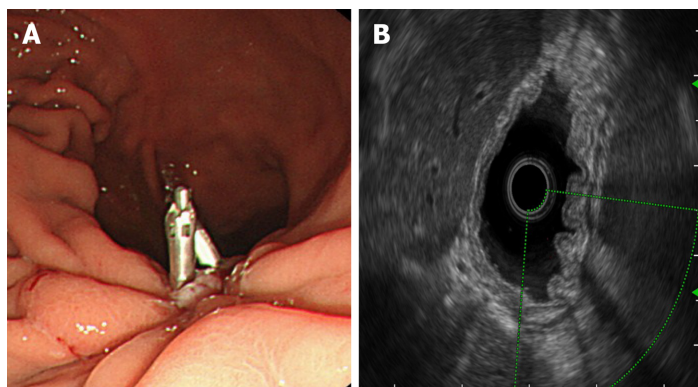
Endoscopic ultrasonography. A: Wound healing, residual small ulcer and metal clip; B: Focus scar area showing thickening and hyperechoic changes, with no blood flow signals on ultrasonic Doppler.
